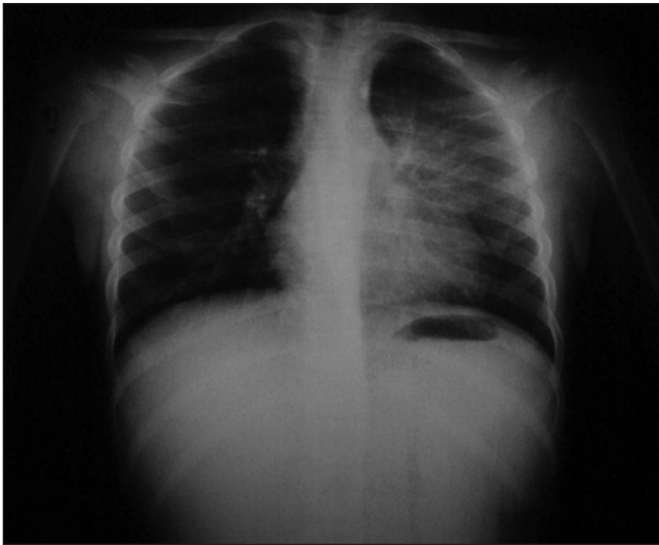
Frontal chest radiograph showing a poorly defined opacity in the left hemithorax with no defined boundaries, which suggests the presence of an extrapulmonary component
